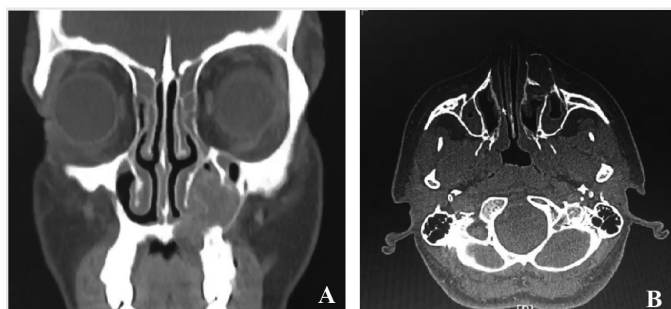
Computed tomography in coronal and axial sections of paranasal sinuses showing a 32x22 mm expansile lesion involving the left maxillary bone. This lesion causes an erosion in the anteromedial wall of left maxillary sinus and the mass reaches the subcutaneous tissue
